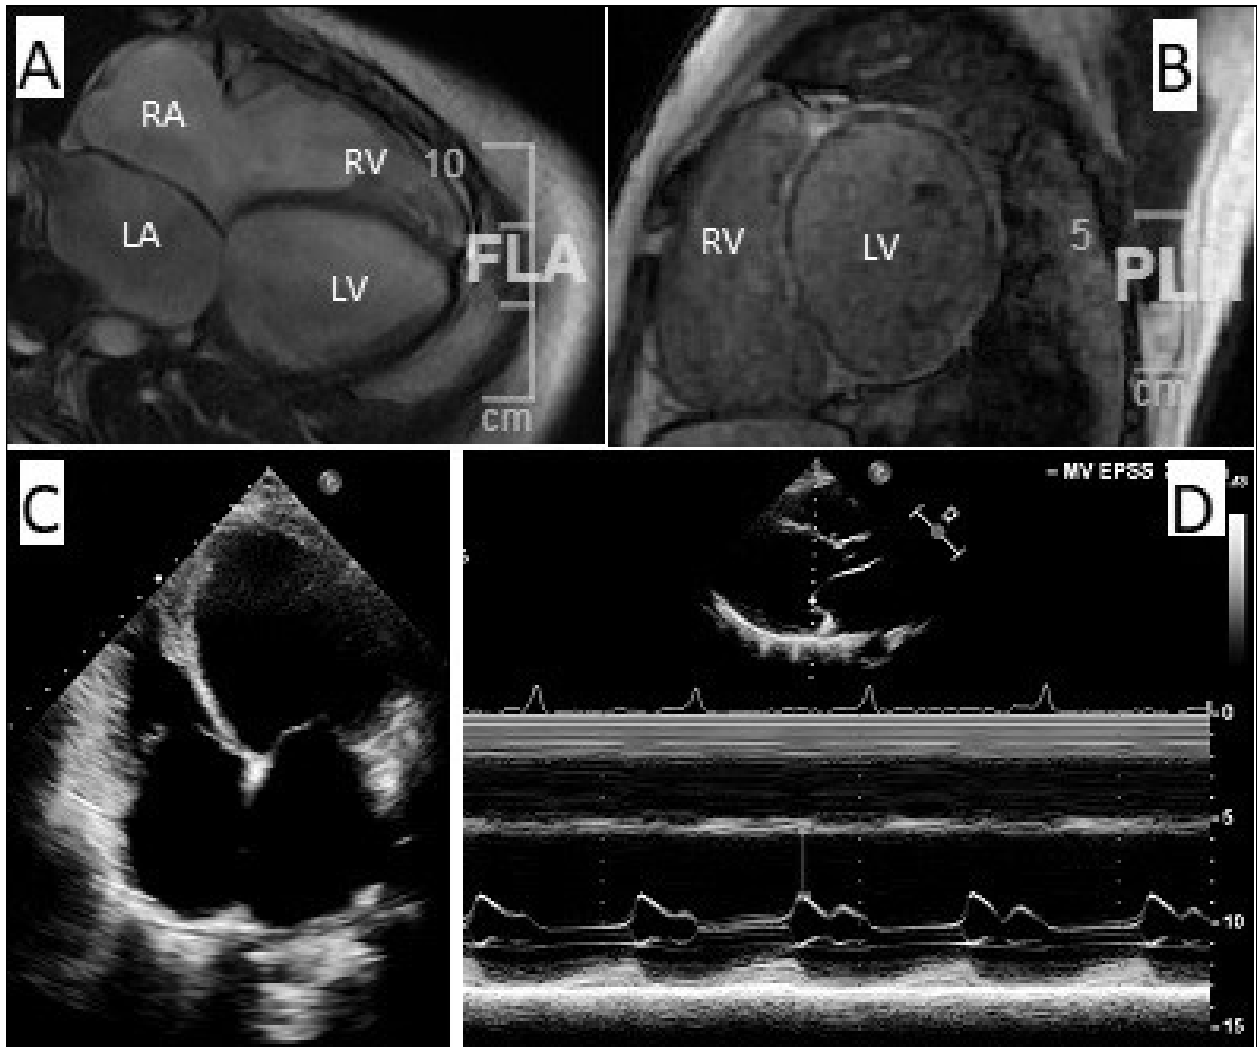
Cardiac MRI and repeat echocardiogram. 4A: Cardiac MRI showing four dilated chambers. 4B: cardiac MRI showing a cross-sectional view of dilated LV and RV. 4C: Repeat echocardiogram showing dilated cardiac chambers. 4D: Repeat echocardiogram M-Mode showing dilated LV and RV.
